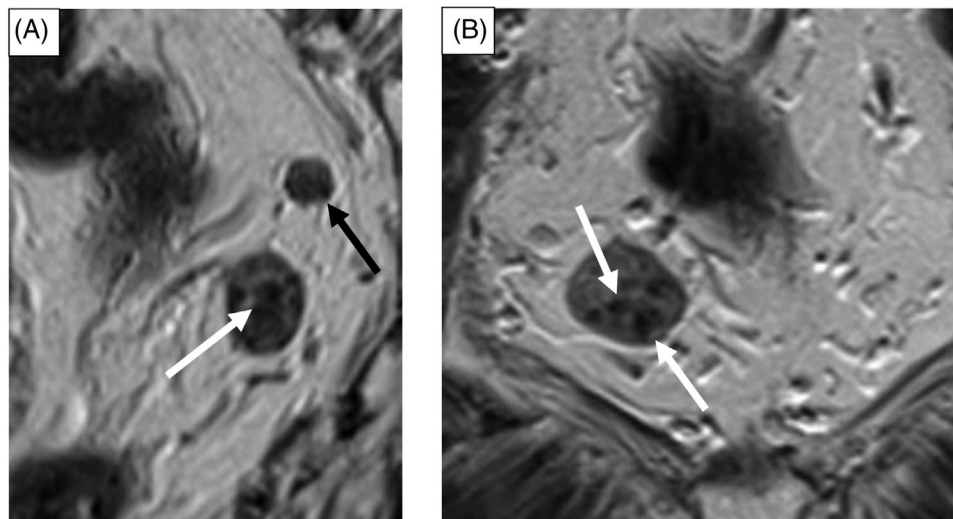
(A and B) Morphological criteria for calling lymph nodes malignant on magnetic resonance imaging (MRI). These include an irregular outline (black arrow) corresponding to extracapsular spread and internal heterogeneity (white arrow) corresponding to intranodal tumor deposits. The features may be present singly or combined but should be confirmed on two high-resolution T2 planes. Visible on (a) sagittal and (b) coronal oblique.
